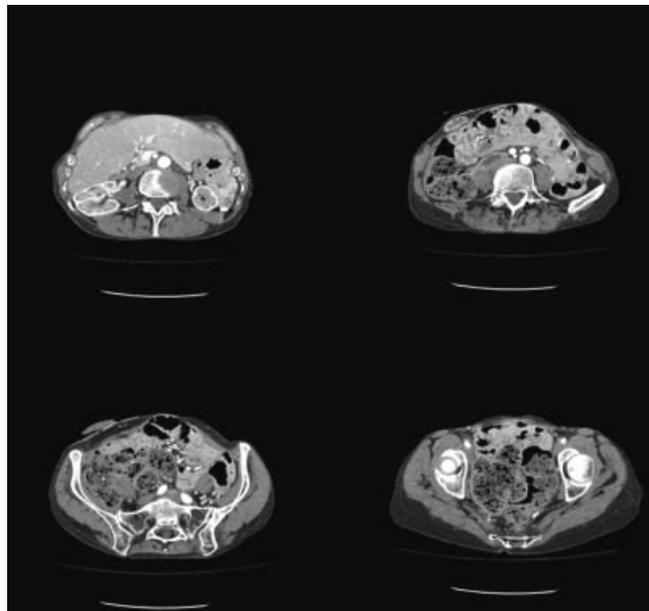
Representative CT Scan images (March 3, 2010) 4.5-years after operative intervention with HIPEC demonstrating minimal residual disease.
